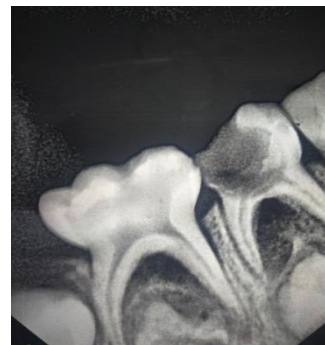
Pre-operative intraoral periapical radiographs of mandibular right first primary molar.
